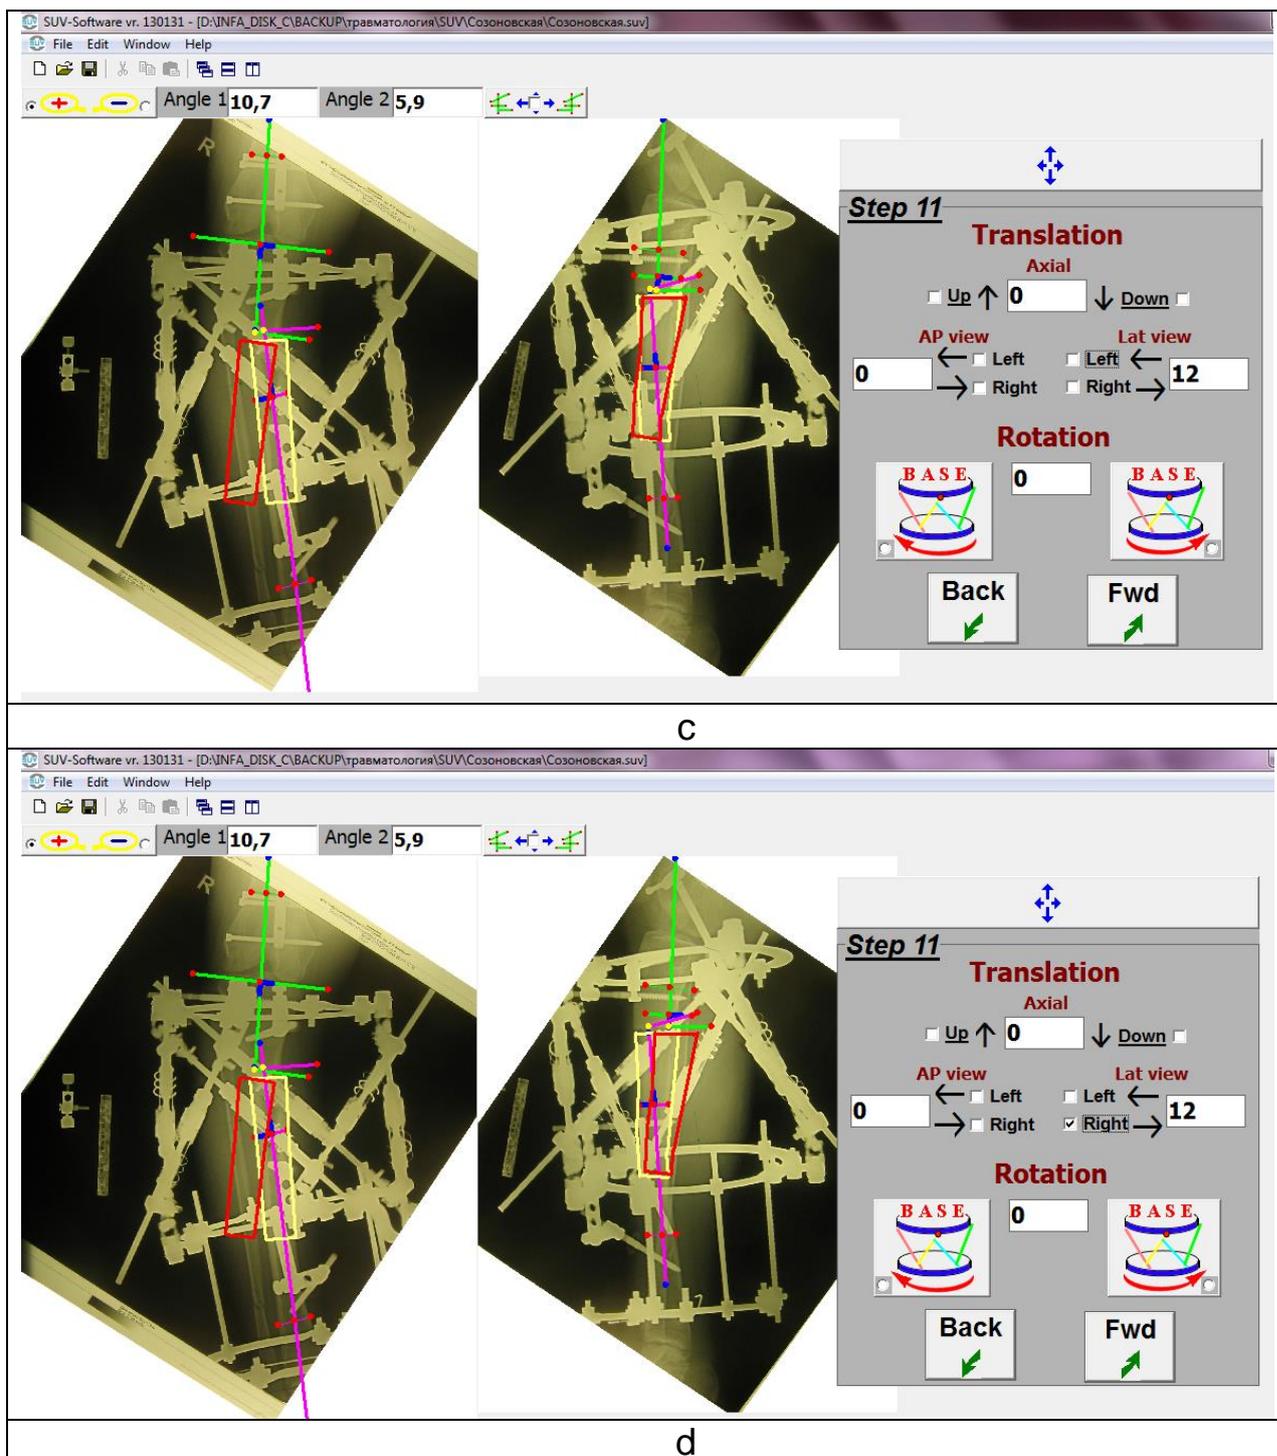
Ortho-SUV program window in Step 11: horizontal moving (translation) of red bone contour. a - necessary value (11 mm) of translation is inserted into field "AP view". b - button "Left" is clicked. It has led to moving of red bone contour to the left on AP view. Note, that "to the left" in this case means "inwards". c - necessary value (14 mm) of horizontal moving is inserted into field "Lat view". d - button "Right" is clicked. It has led to moving of red bone contour to the right on Lat view. Note, that "to the right" in this case means "back"
